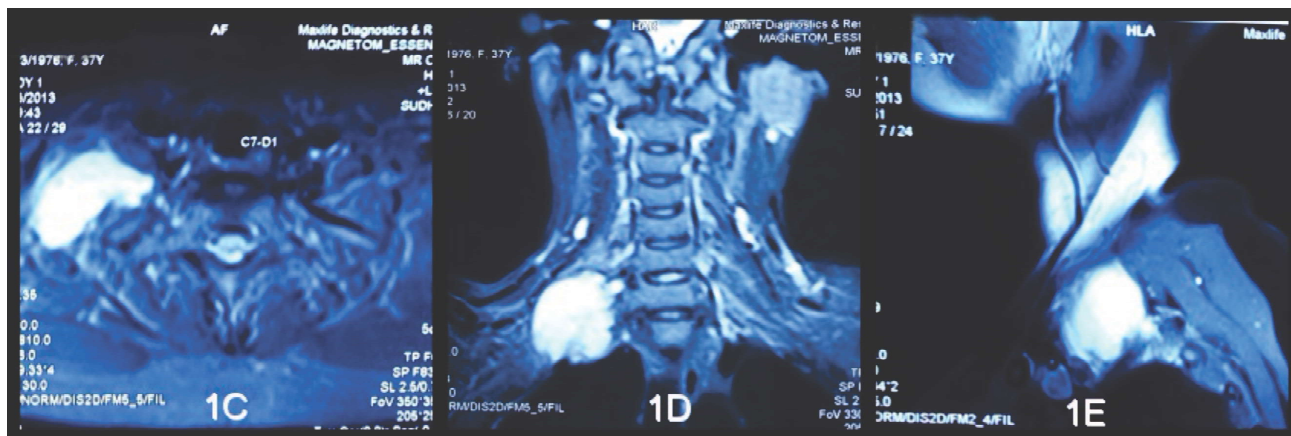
(C,D,E) Gadolinium enhanced T1-weighted coronal image showing homogeneous brilliant enhancement of the right supraclavicular lesion.
